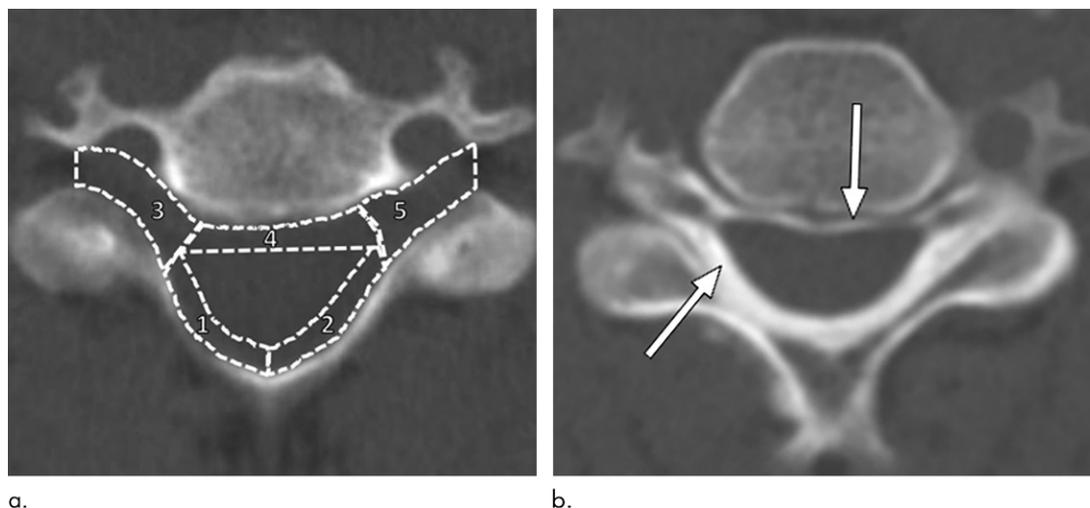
Axial CT images in a 55-year-old woman with neck pain and bilateral upper extremity radicular pain, right side greater than left side. Cervical interlaminar epidural steroid injection was performed on the right side in vertebrae C3/C4. (a) Preprocedural noncontrast-enhanced image in vertebrae C4/C5 shows a classification scheme for location of injectate spread. Regions include ipsilateral dorsal epidural space (zone 1), contralateral dorsal epidural space (zone 2), ipsilateral neuroforamen (zone 3), ventral epidural space (zone 4), and contralateral neuroforamen (zone 5). (b) Postprocedural image in vertebrae C4/C5 shows epidurography contrast material (arrows) spread to all zones.
